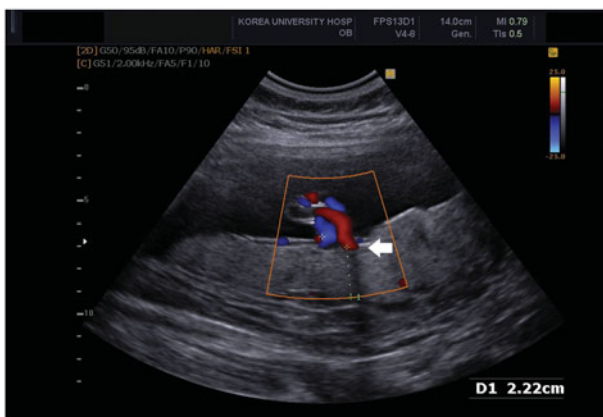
Measurement of placental thickness using ultrasonography during the second trimester. The placental thickness measured at the insertion site of the umbilical cord (white arrow), with a thickness of 2.22 cm.
